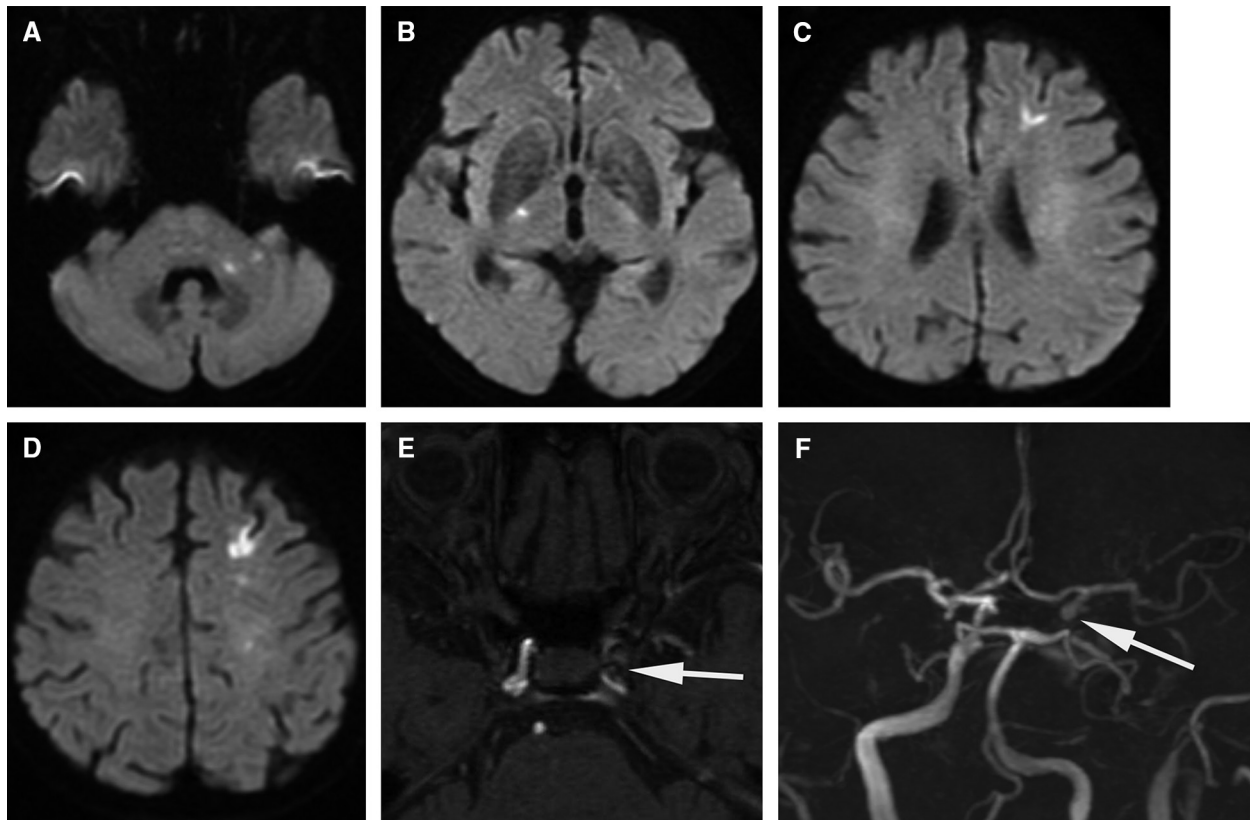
DWI at onset showed a high-intensity area in left superior cerebellar peduncle (A), right corona radiata (B), and left frontal lobe (C, D). MRA-TOF showed a significantly low-intensity area around
